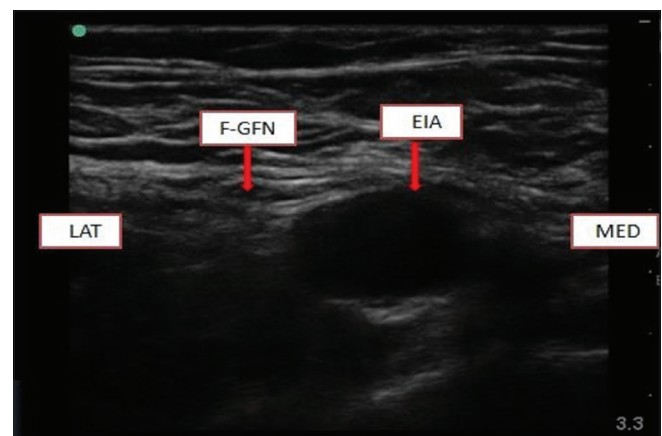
Ultrasonographic image showing Femoral branch of Genitofemoral nerve lateral to external iliac artery at supra-inguinal level. F-GFN: Femoral branch of genitofemoral nerve, EIA: External iliac artery, MED: Medial side, LAT: Lateral side
